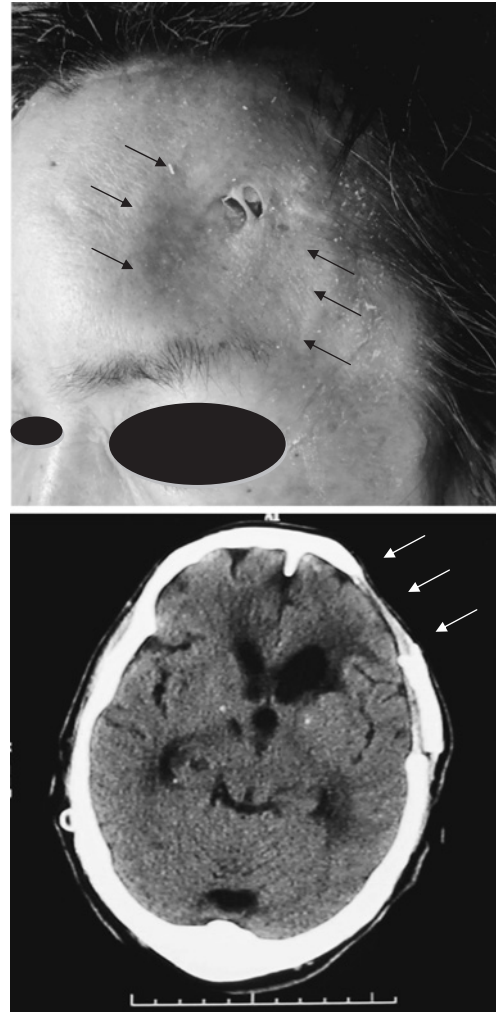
56 year-old female exhibiting a skin ulcer with a dura and bone sequestrum exposure on her forehead. (above) Left oblique view. The area of the bone defect was noticed by the depressed region (black arrow). (below) CT image showed cranial bone defect of the left frontal area (white arrow) and non-bony union between bone flap and the adjacent cranium.
